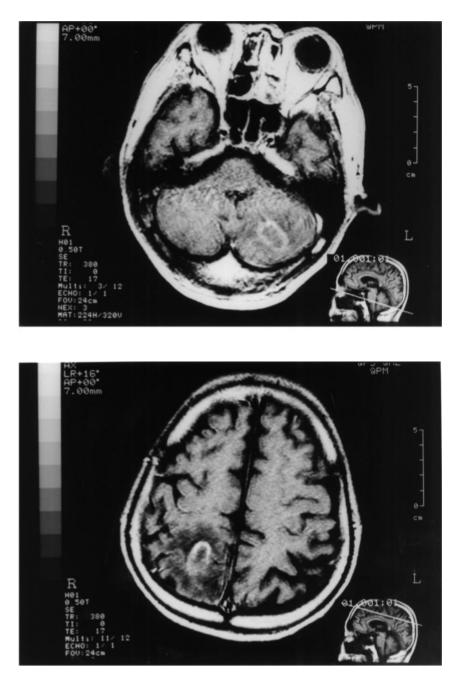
Magnetic resonance imaging (MRI) of the brain at the initial diagnosis demonstrated multiple ringed-enhanced space-occupying lesions. The upper panel shows a lesion in the left hemisphere of the cerebellum, and the lower panel shows one in the right occipital lobe of the cerebrum.
